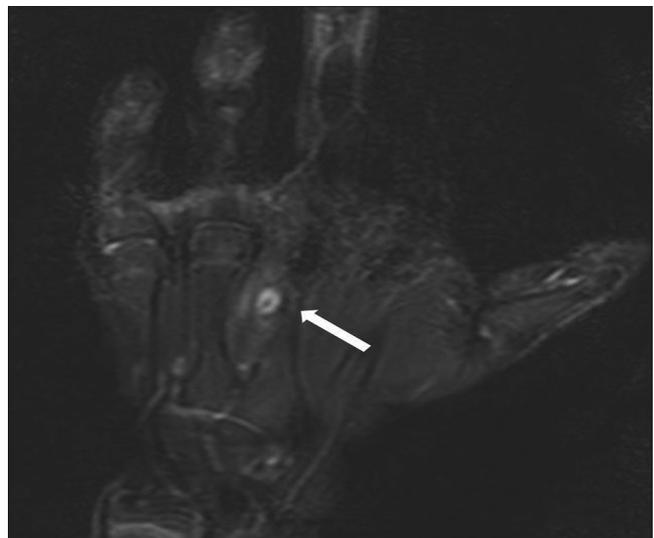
MRI -T2 weighted image (coronal plane) – shows a linear hypointense structure in the central region with peripheral hyperintense area (arrow) adjacent to the 3rd metacarpal.
